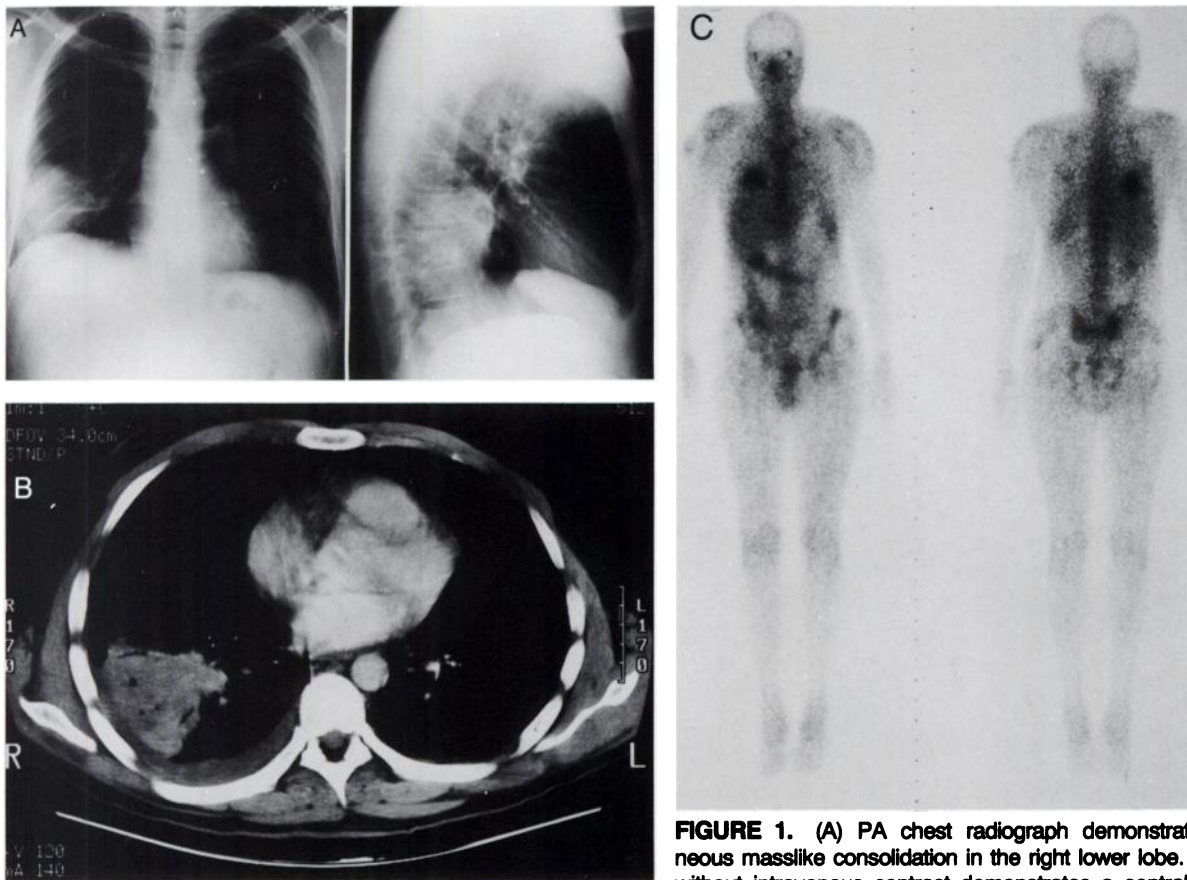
(A) PA chest radiograph demonstrates homogeneous masslike consolidation in the right lower lobe. (B) CT scan without intravenous contrast demonstrates a central area of decreased attenuation in the mass and associated with pleural effusion. (C) Gallium-67 scan at 24 hr postinjection demonstrates increased uptake of ^{67}Ga in the right lower lung field.
